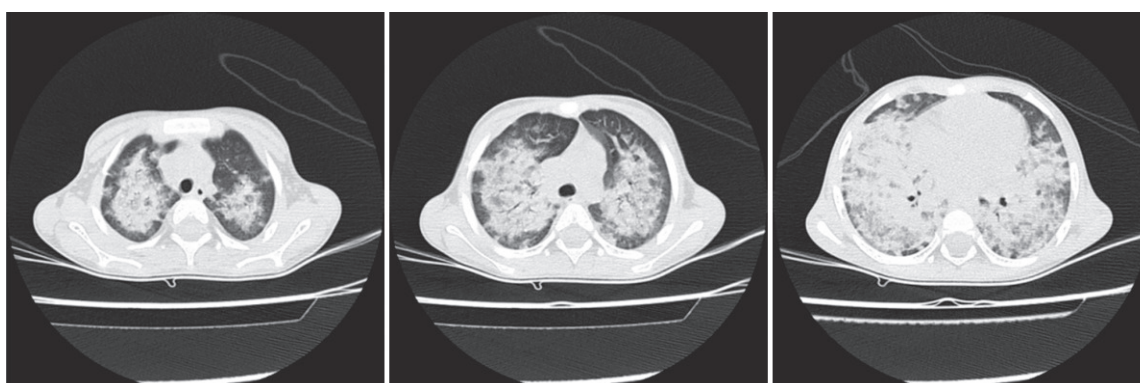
CT Thorax showing Extensive pneumonic air space consolidation in all lobes of both lungs.
